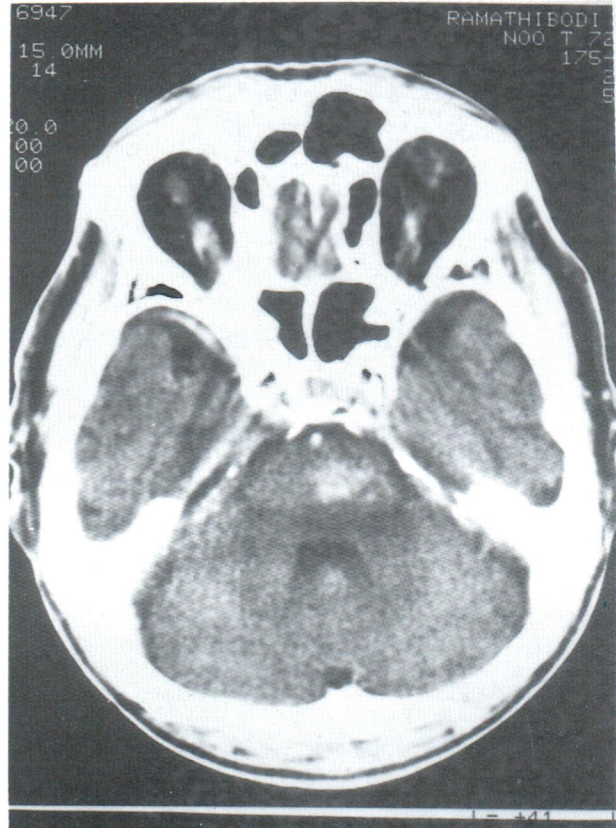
CT shows left pontine hematoma
